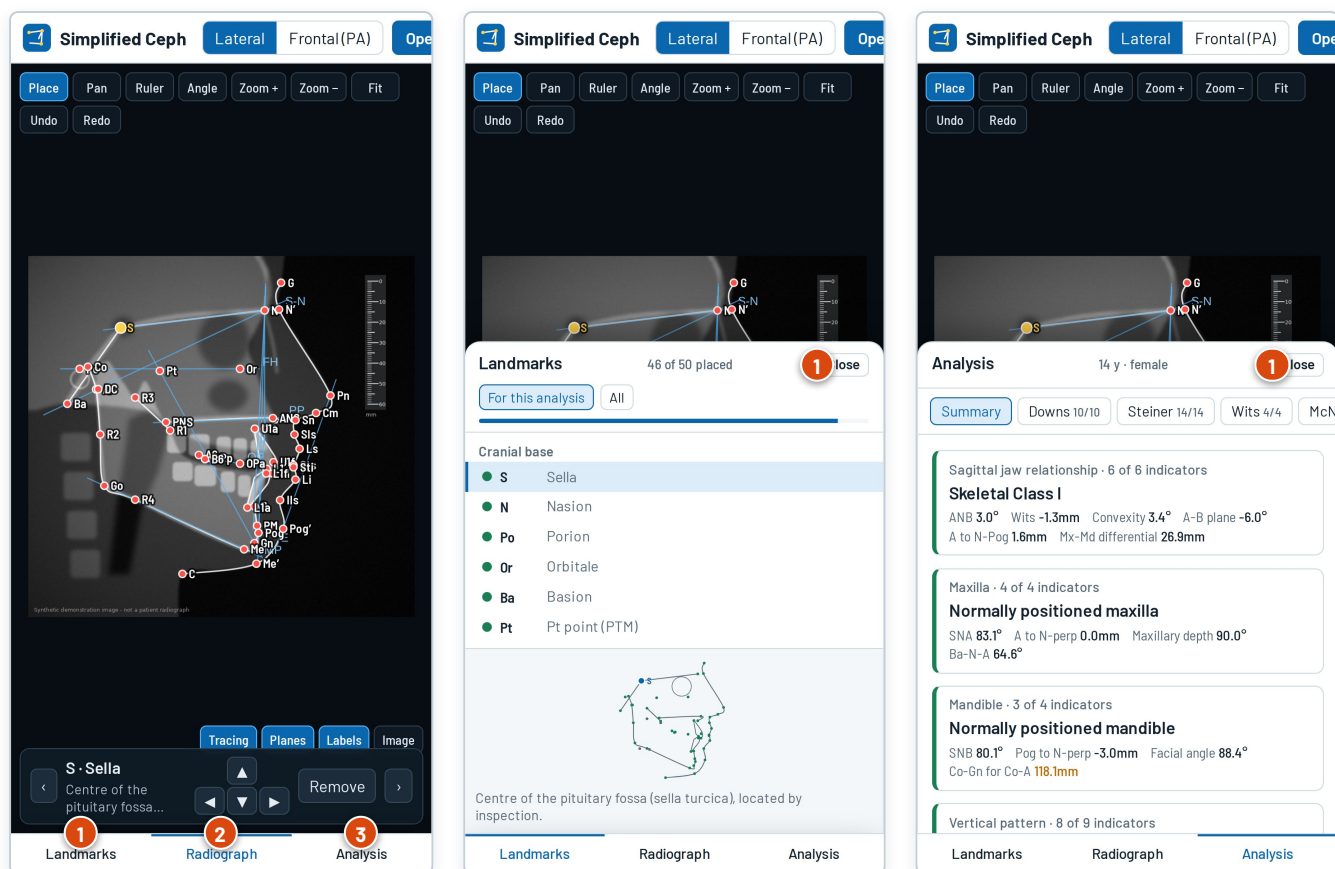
Phone layout. Left: the X-ray with 1 Landmarks, 2 Radiograph and 3 Analysis tabs. Middle: the Landmarks sheet. Right: the Analysis sheet. Each sheet has a Close button (1).
